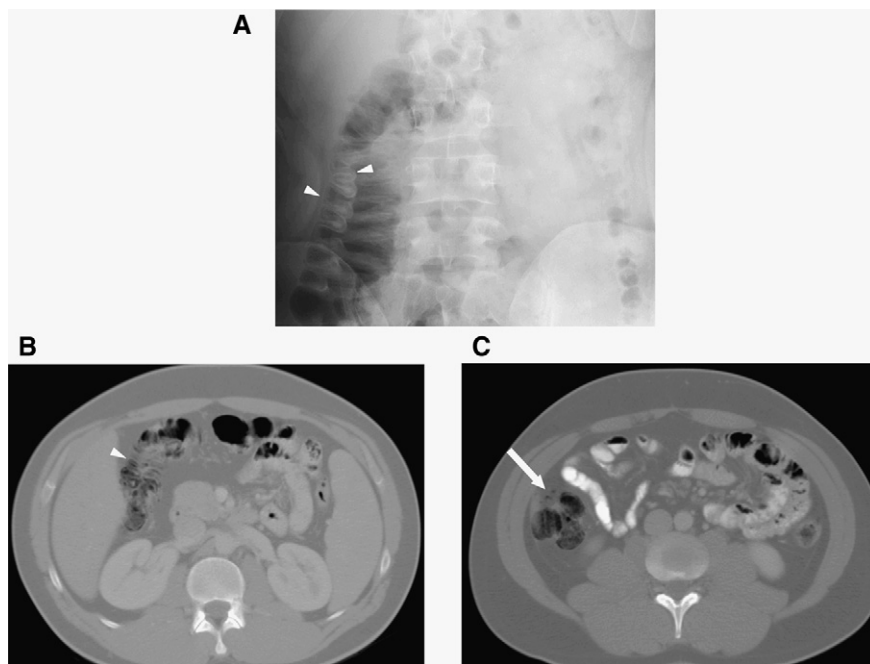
Pneumatosis intestinalis developing in a patient diagnosed with chronic myelogenous leukaemia 12 weeks after starting therapy with the tyrosine kinase inhibitor imatinib. (A) Left lateral decubitus plain radiograph, showing intramural gas (arrowheads) in the ascending colon. (B) Axial computed tomographic images of the abdomen confirms intramural gas in transverse and ascending colon (arrowhead). (C) Small foci of extraluminal gas (arrow) is consistent with localized perforation of the colon.
